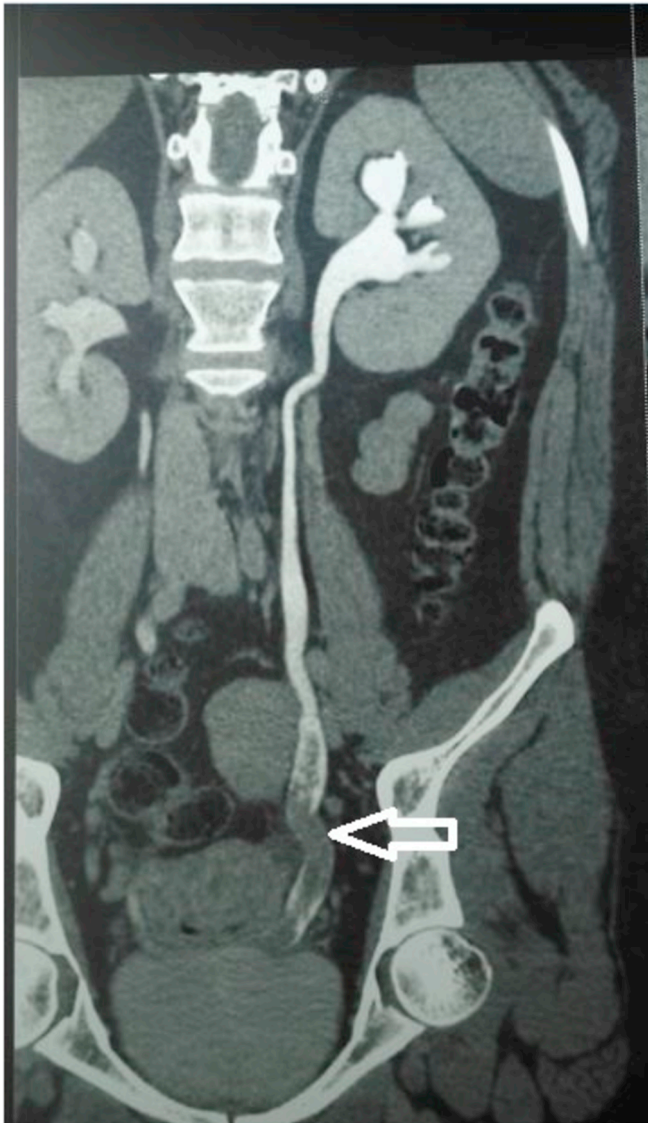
Contrast-enhanced abdominal computed tomography showed a 5 cm intra-luminal ureteral lesion that is obstructive with homogenous contrast enhancement.
